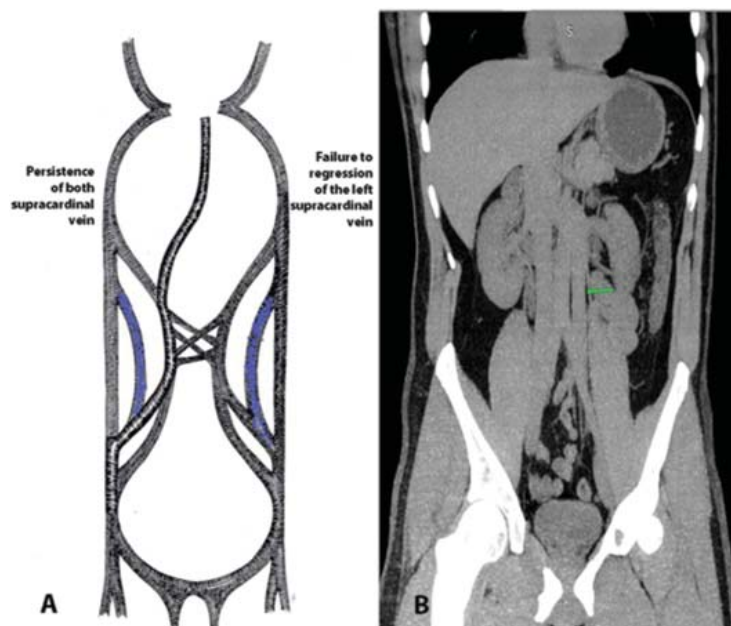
BDIVC. A – embryonic etiology of the BDIVC. B – Abdominal CT in the coronal plane of the BDIVC
